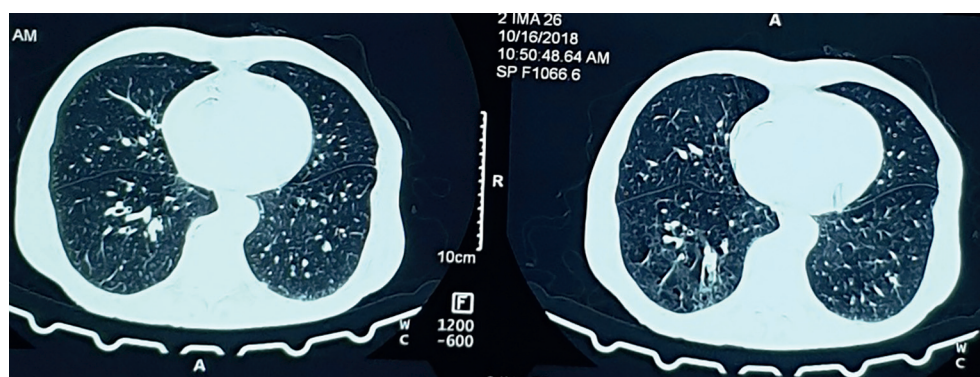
HRCT Thorax showing centrilobular nodules & tree in bud opacities in bilateral lower lobes.
